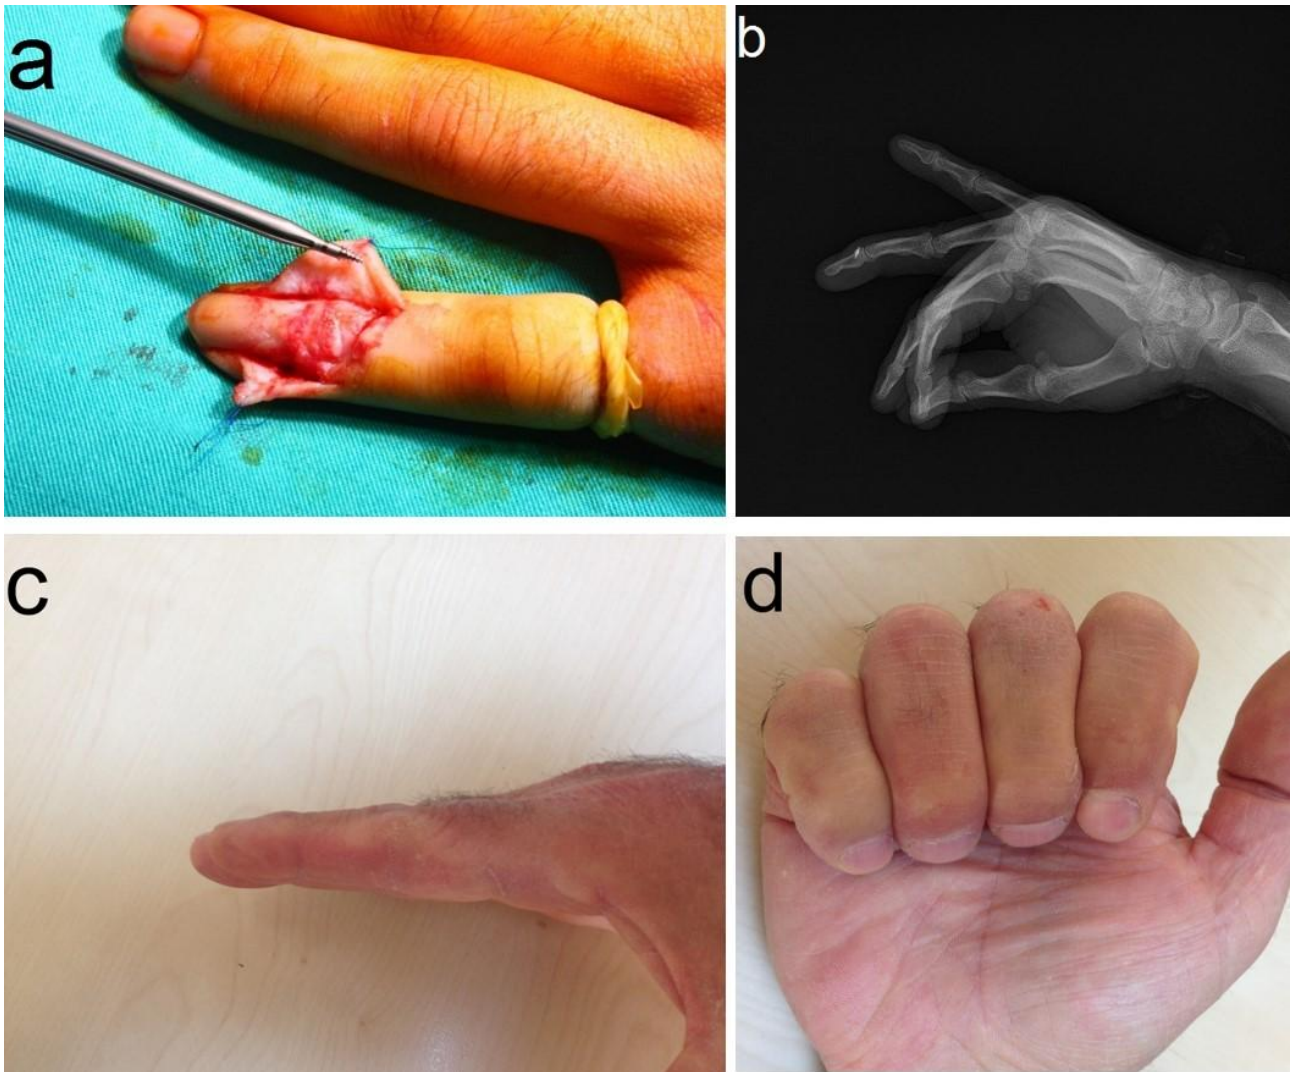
Images of micro-bone anchor fixation of non-osseous mallet finger deformity; (a) intra-operative image, (b) postoperative radiograph, and (c, d) functional results of the right ring finger at postoperative 14 months.
